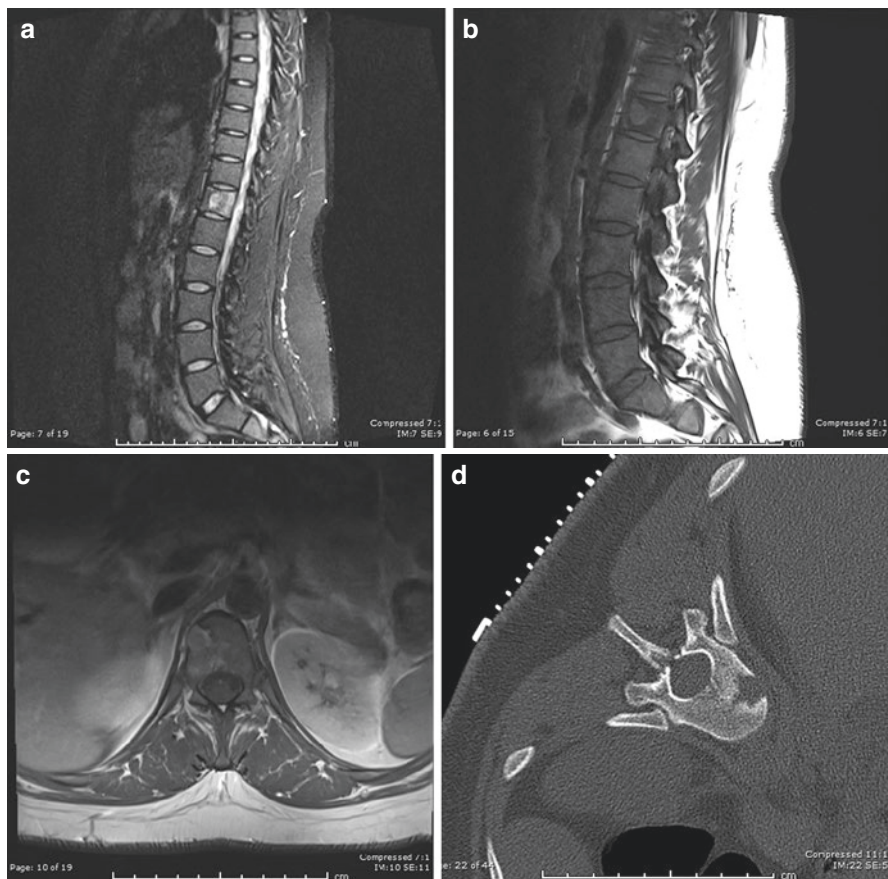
(a and b) Sagittal MRI scan of an 18-year-old with an eosinophilic granuloma at T12. Note the preservation of discs which tends to rule out infection as a potential cause of the lesion. (c and d) Axial MRI scan and CT scan of the above patient. Note paucity of soft tissue reaction
